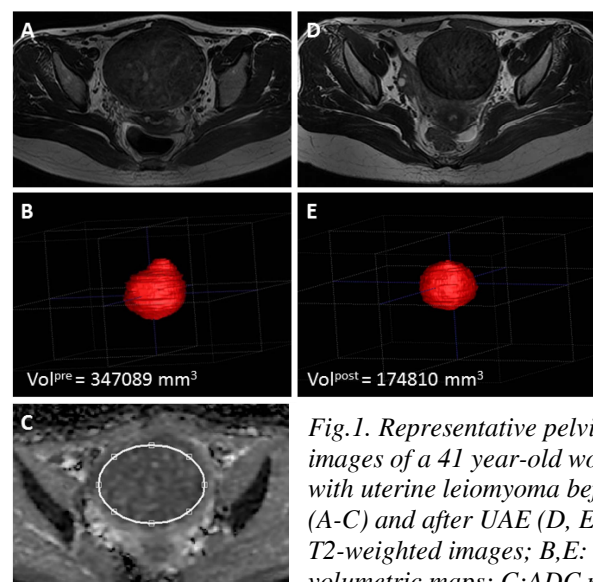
Representative pelvic images of a 41 year-old women with uterine leiomyoma before (A-C) and after UAE (D, E). A, D: T2-weighted images; B, E: 3D volumetric maps; C: ADC map
